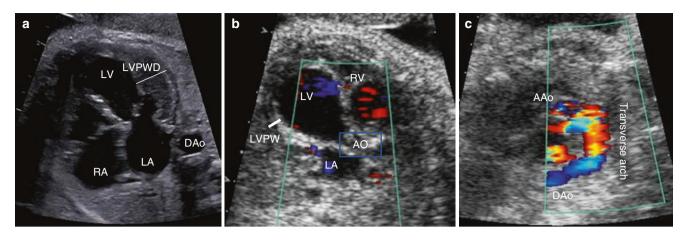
Fetal echocardiography images of critical aortic stenosis. (a) This fetus has developed severe ventricular hypertrophy due to slow progression of aortic stenosis. (b) Another fetus with aortic stenosis that either was more severe or developed in earlier gestation resulting in endocardial fibroelastosis and a hypoplastic left ventricle. (c) Retrograde
